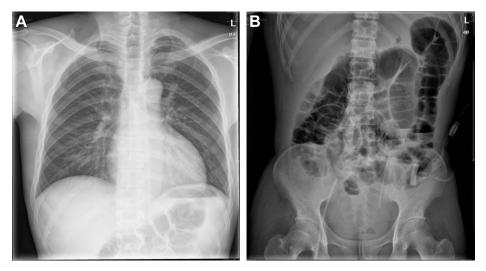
(A) Chest radiograph showing normal findings (9/11/2012). (B) Upright abdominal radiograph (9/21/2012) showing marked gaseous abdominal distension and short air fluid levels. The end of the catheter was at lumbar level 4.
